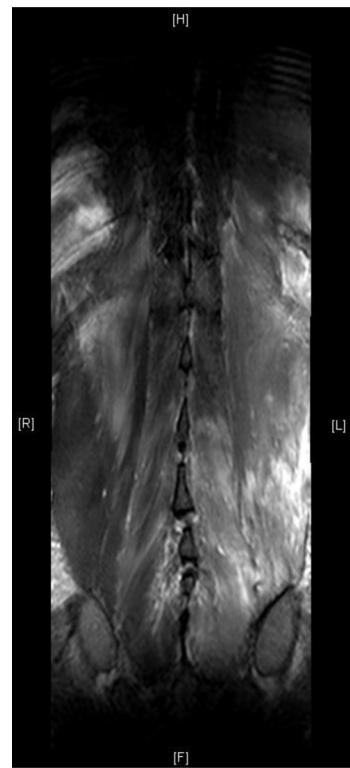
MRI lumbar spine with contrast showing enhancement and increased signal of the left erector spinae muscle complex consistent with acute myositis and rhabdomyolysis.
